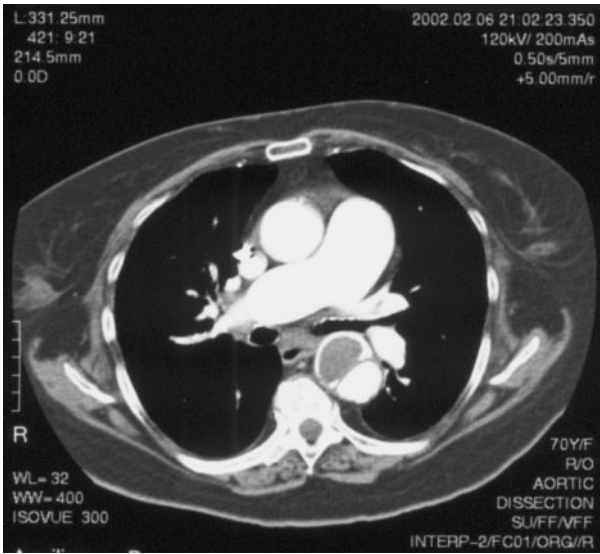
Contrast computed tomography scan of descending thoracic aorta demonstrating a medial saccular aneurysm versus a localized type B dissection.
